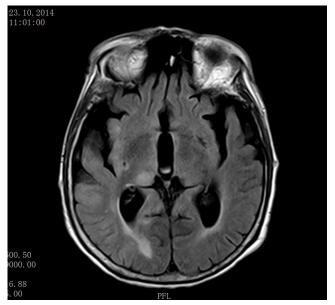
Flair image of control MRI scan presenting regression of intensity changes at first week of the treatment
